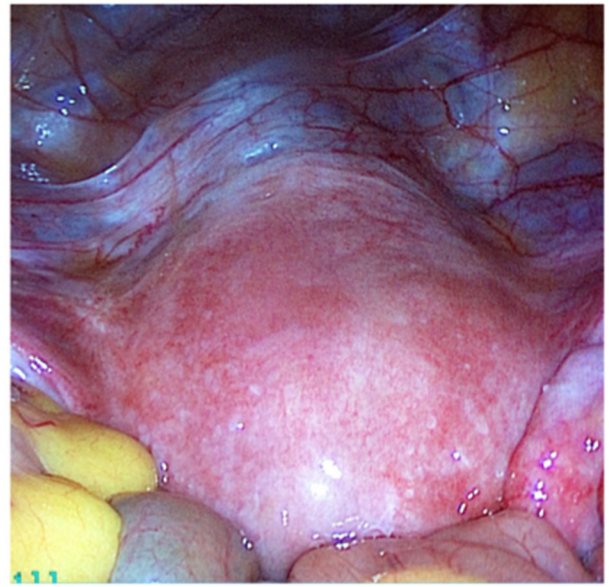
Laparoscopic image of the intact perimetrium above the ultrasonographically identified isthmocele.
